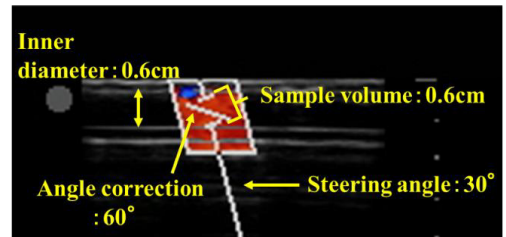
Measurement of blood flow velocity waveform with ultrasonic diagnostic equipment
